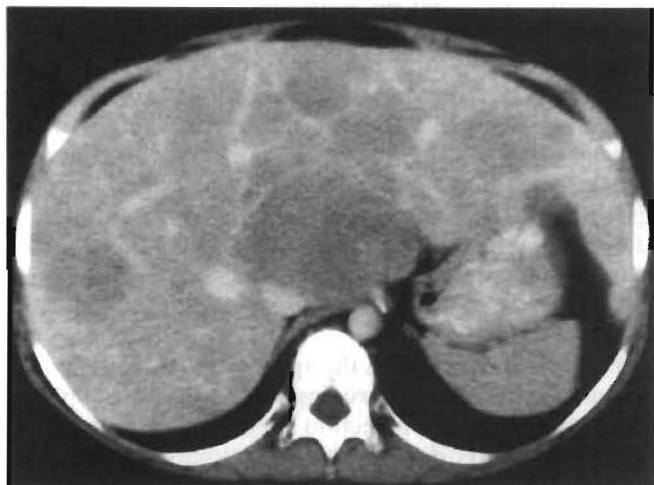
Pre OLTx CT scan, case no. 4. Multiple hepatic mass lesions of various sizes are spread throughout the entire liver
